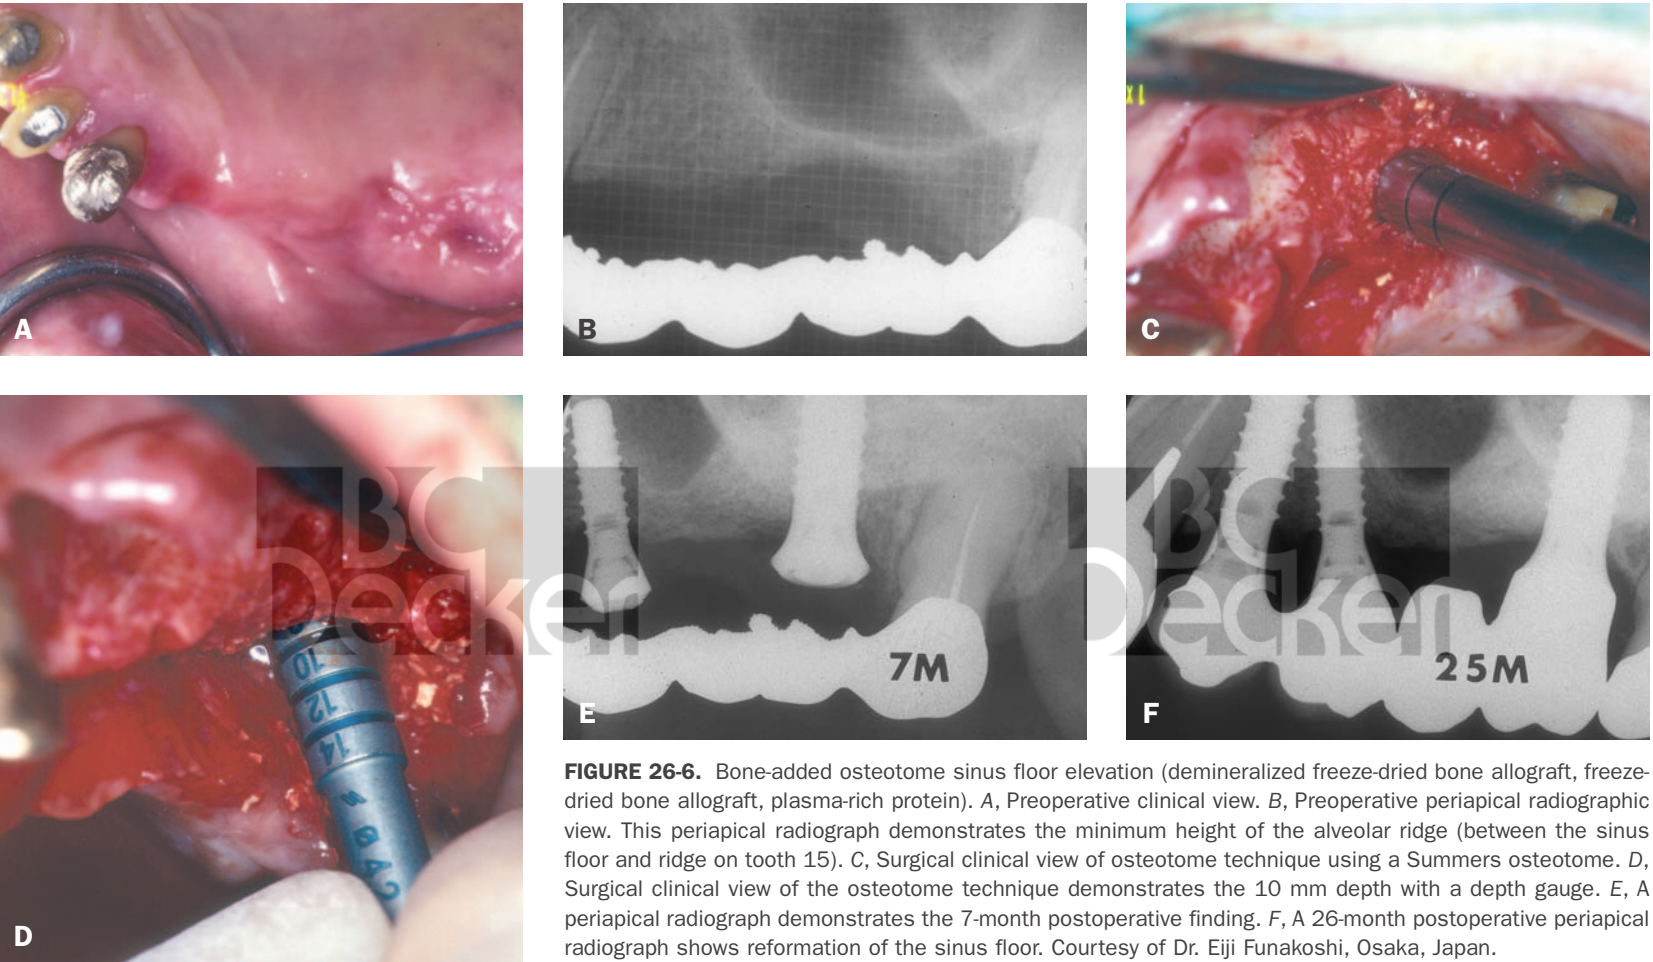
Bone-added osteotome sinus floor elevation (demineralized freeze-dried bone allograft, freeze-dried bone allograft, plasma-rich protein). A, Preoperative clinical view. B, Preoperative periapical radiographic view. This periapical radiograph demonstrates the minimum height of the alveolar ridge (between the sinus floor and ridge on tooth 15). C, Surgical clinical view of osteotome technique using a Summers osteotome. D, Surgical clinical view of the osteotome technique demonstrates the 10 mm depth with a depth gauge. E, A periapical radiograph demonstrates the 7-month postoperative finding. F, A 26-month postoperative periapical radiograph shows reformation of the sinus floor. Courtesy of Dr. Eiji Funakoshi, Osaka, Japan.
